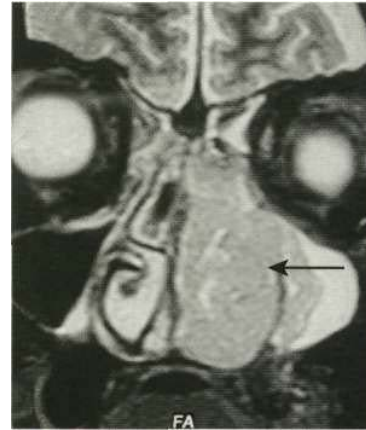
MRI of sinonasal tumour. Large soft tissue swelling filling nasal cavity and sinuses on the patient's left side.
